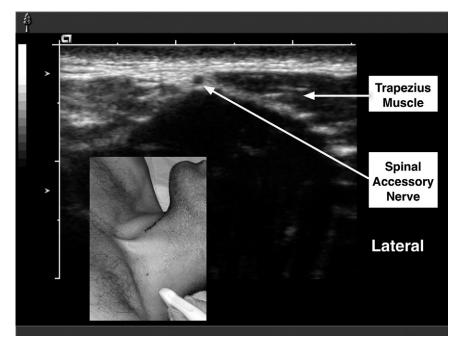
Sonogram of the spinal accessory nerve at the border of the trapezius muscle. The nerve is seen in short axis (transverse cross-section). Large tickmarks are 10 mm apart. Inset panel: The approximate ultrasound transducer position. The head is positioned for interscalene block.
